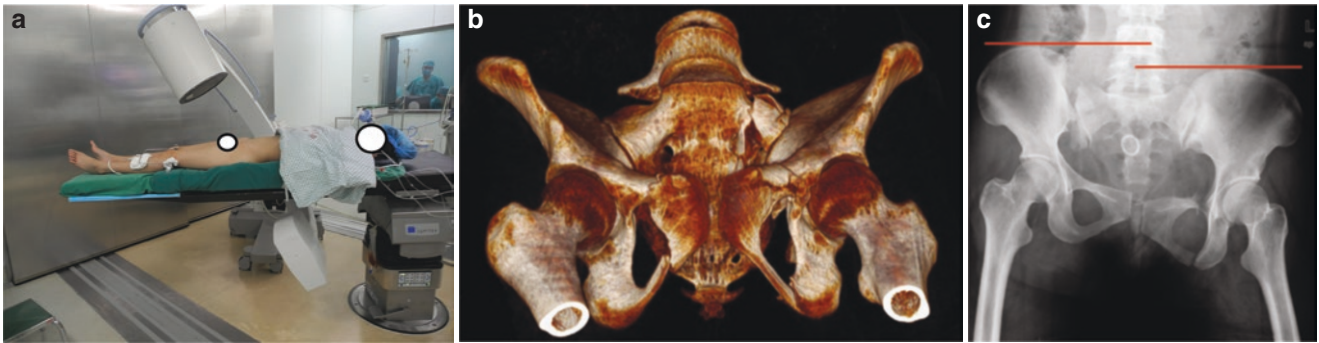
(a) AP projection of the pelvis. (b) A 3D model reconstructed from CT images showing the position of the pelvis under an AP projection. (c) Pelvic AP plain radiograph: There is a fracture of the left L5 transverse process, suggesting that the pelvis is longitudinally unstable
